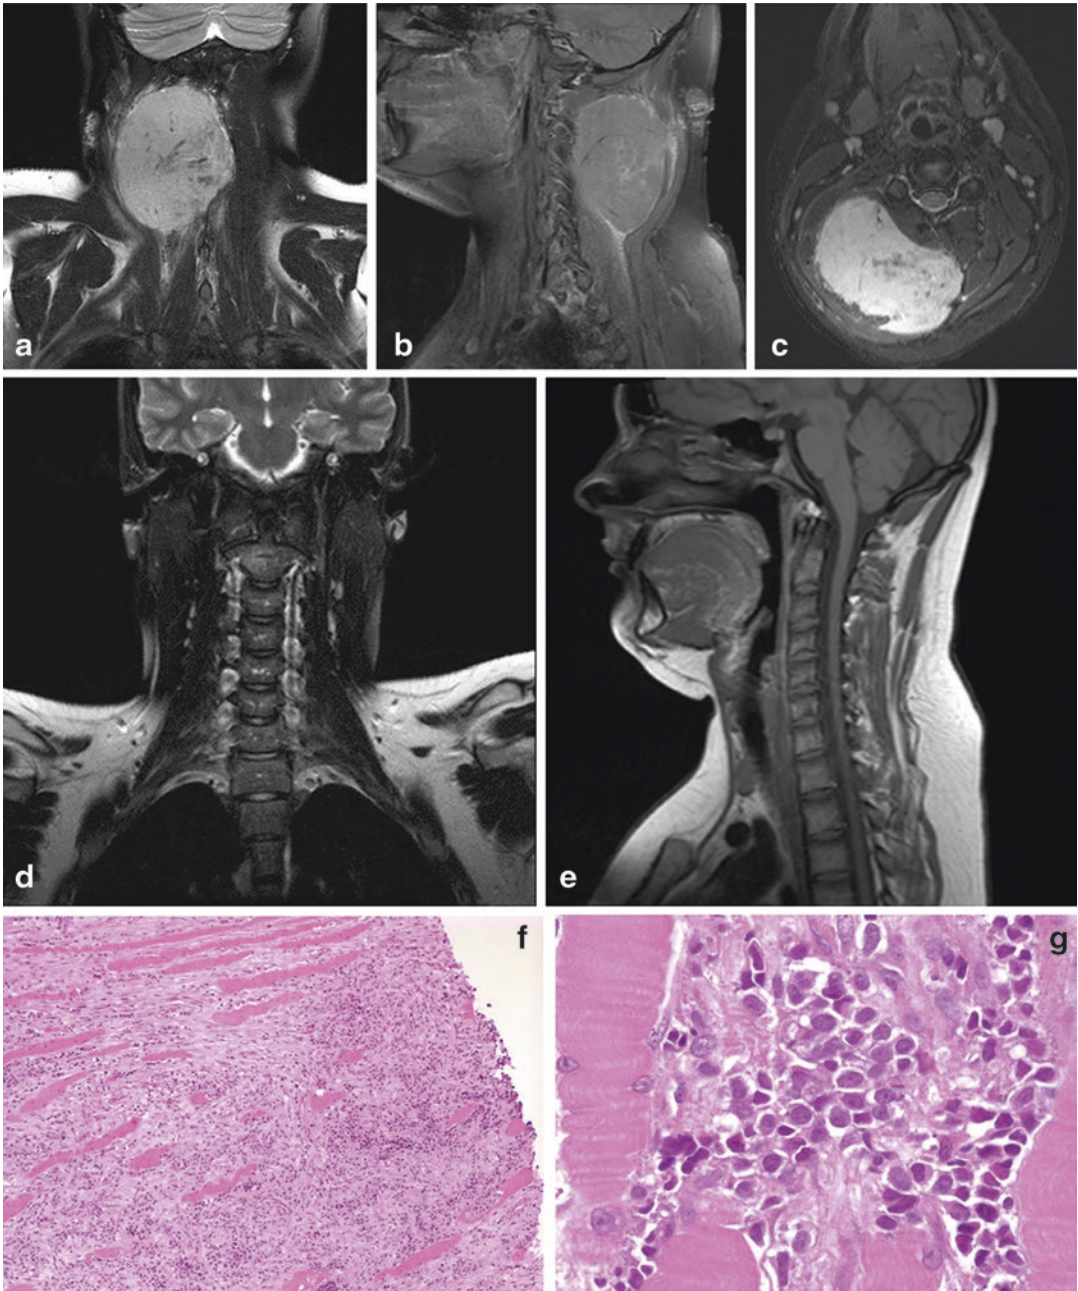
(a–g) MRI of child with Ewing sarcoma. (a, b, c) Coronal, sagittal, and axial MRI showing isointense T_1 and hyperintense T_2 soft tissue mass arising from right posterior intermediate muscles of the neck; (d, e) coronal
